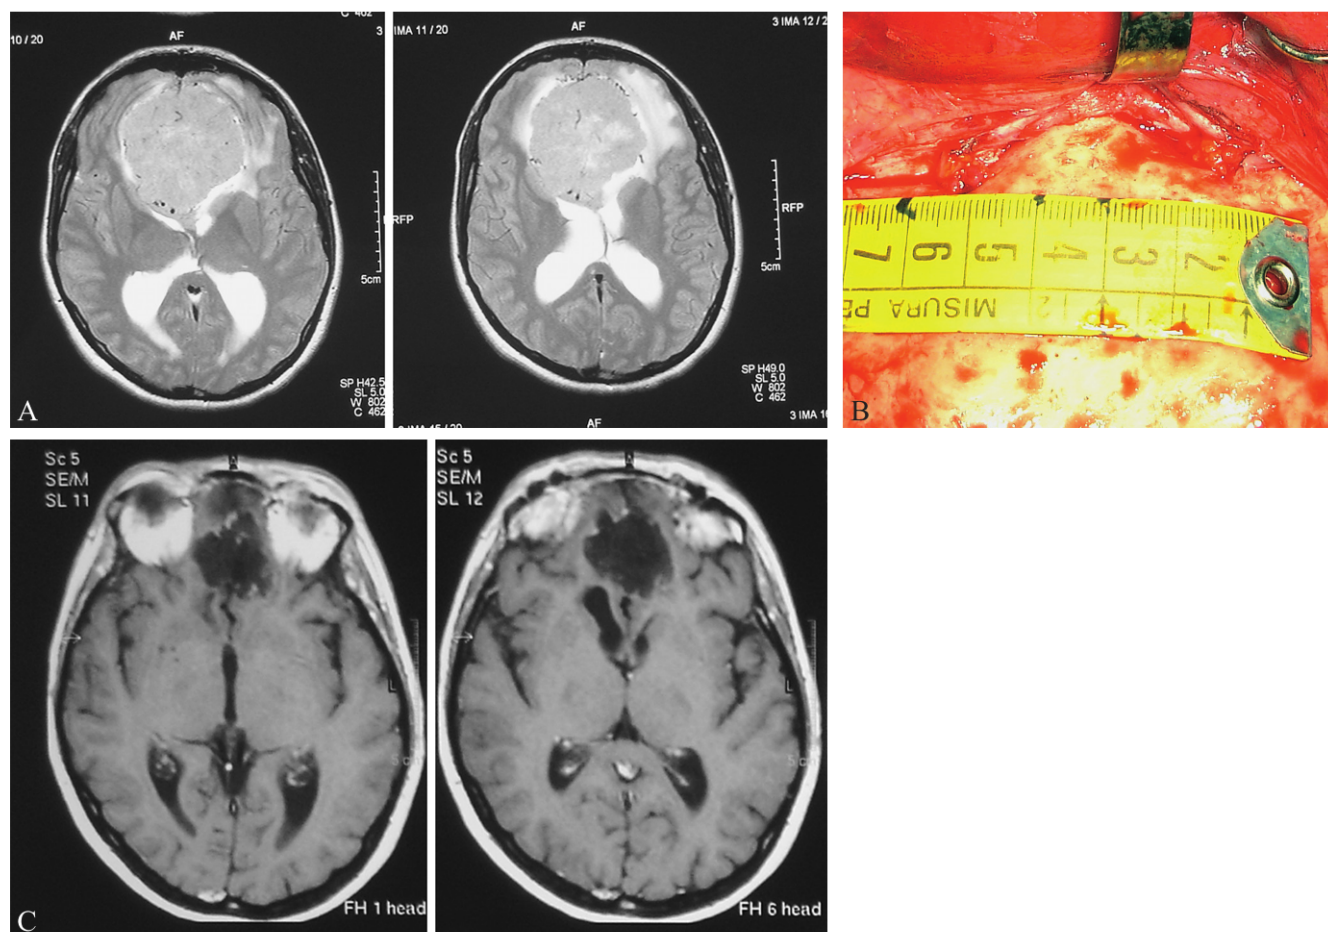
A) Preoperative axial MRI showing a large OGM; B) the osteotomy was tailored according to the size of the frontal sinus and the meningioma as measured by MRI; C) postoperative axial MRI.
